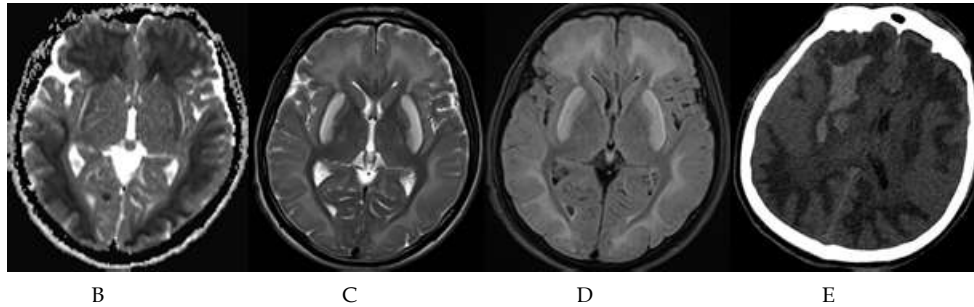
Methanol-induced brain lesions (A) - DWI, (B) - ADC maps demonstrated restricted diffusion in the cerebellum, brain stem, putamen, subcortical white matter; (C) - T2-weighted, (D) - T2 flair MRI showed hyperintensity in the same regions and (E) - CT also showed right putaminal and frontal hemorrhage.
